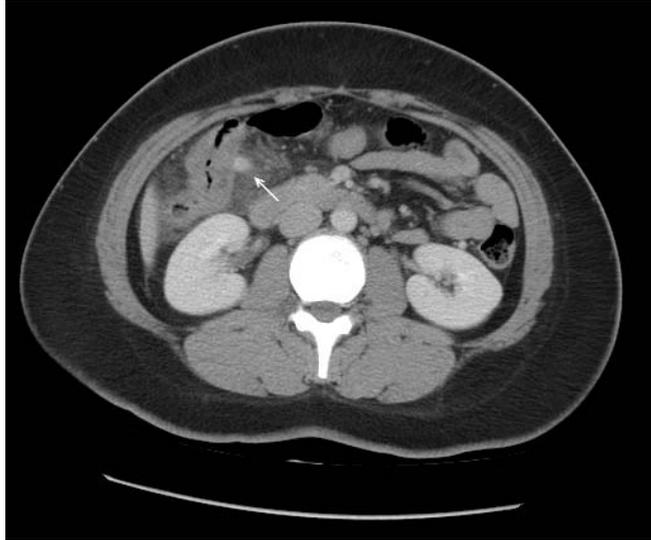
Ascending colon diverticulitis (wall thickening and fat stranding) was seen (arrow) in CT image.
